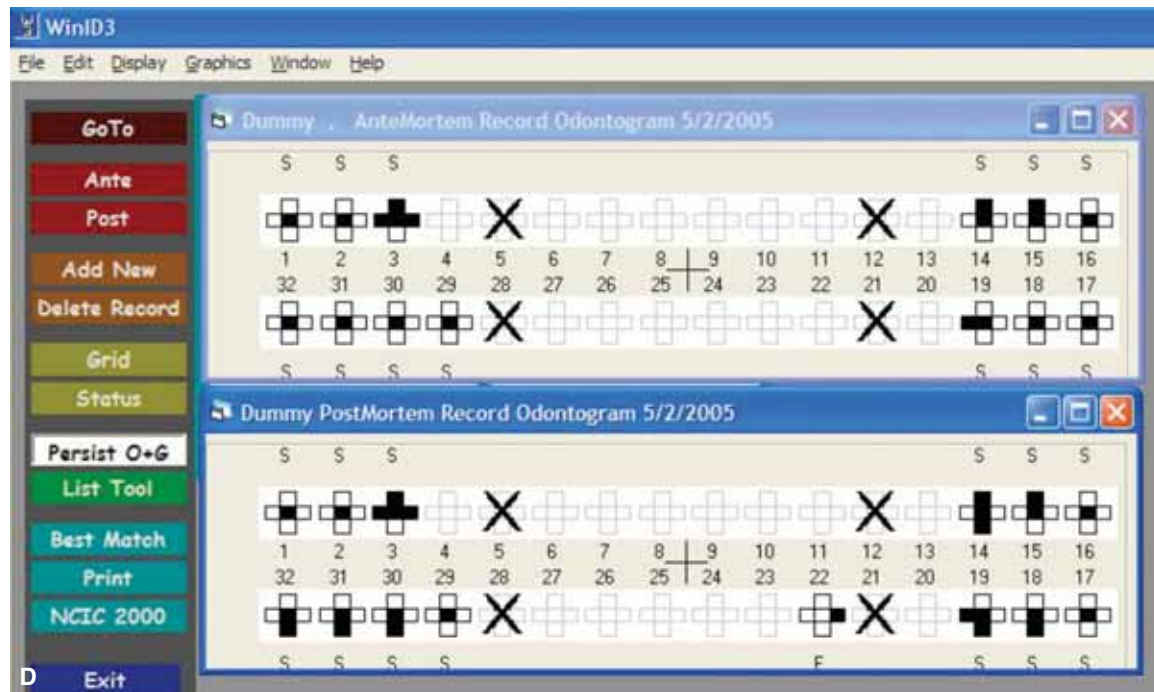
(Continued), D. Antemortem and postmortem information is transferred from the paper charts shown in Figure 12-5A and B to the WinID database. The database can then be used to search all unidentified victims for possible matches to antemortem records. The computer will provide a report as shown here in graphic fashion. The forensic dentist is still required to visually compare the dental radiographs and other examination information to ascertain identity, which was “positive” in this case.
